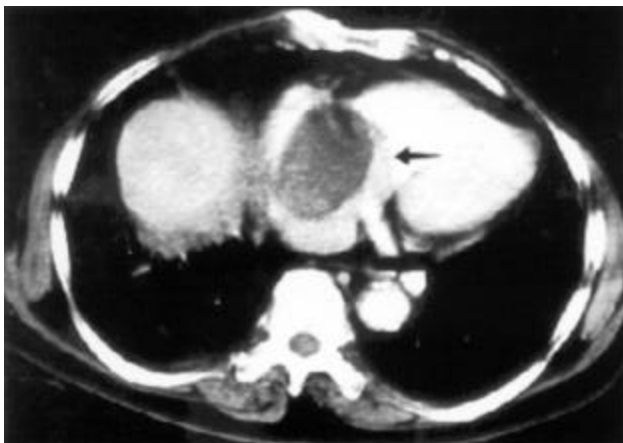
CT scan of the chest after atrial tumor resection.
